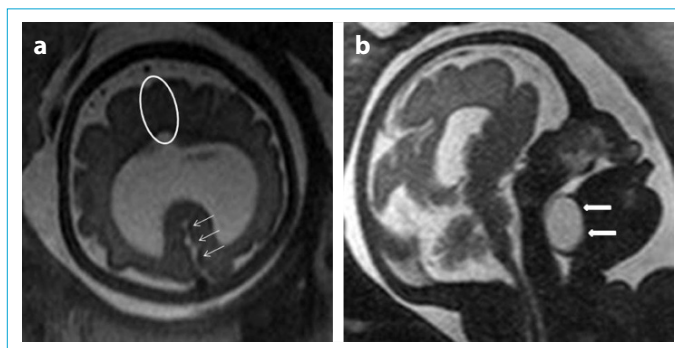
(a, b). (a) Posterior interhemispheric fissure (thin arrows) is seen in T2-weighted axial view, but anterior interhemispheric fissure is not observed (circle) in a fetus with semilobar holoprosencephaly. (b) There is a thyroglossal duct cyst at the posterior of the tongue (thick arrows) in T2-weighted sagittal view.
